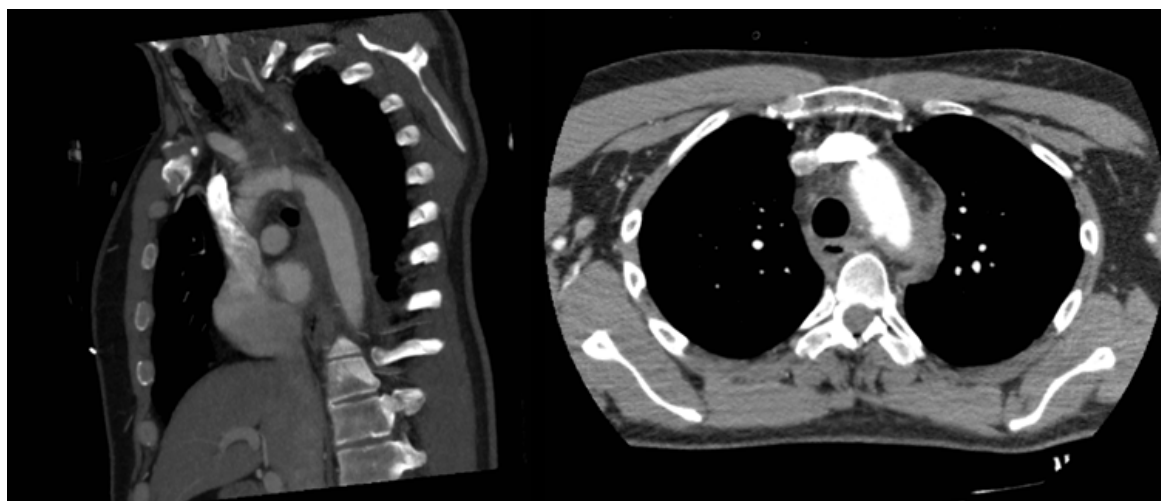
CT chest showing rupture of arch of aorta demonstrating extravasation of contrast and surround hemorrhage.
